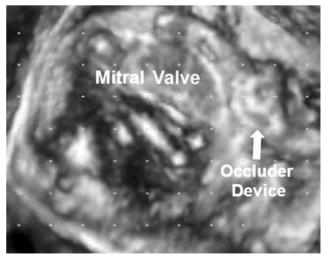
Three-dimensional transesophageal echocardiography showing the ADO II device (arrow) deployed for the mitral paravalvular leak.
